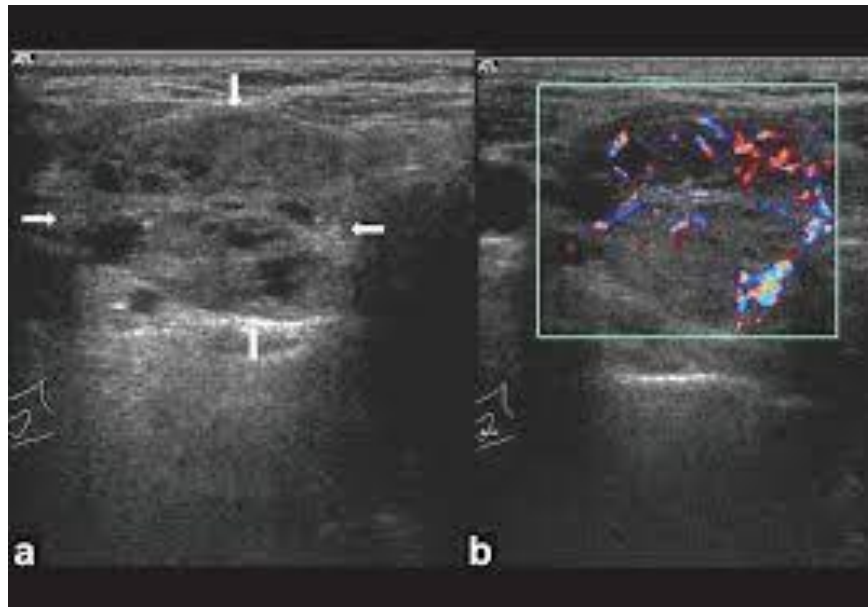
Transverse grey scale sonogram in a patient with known breast carcinoma shows a well-defined solid, homogeneous hypoechoic mass occupying the right lobe of thyroid. FNAC confirmed a metastatic carcinoma. (www.wikipedia.com)
